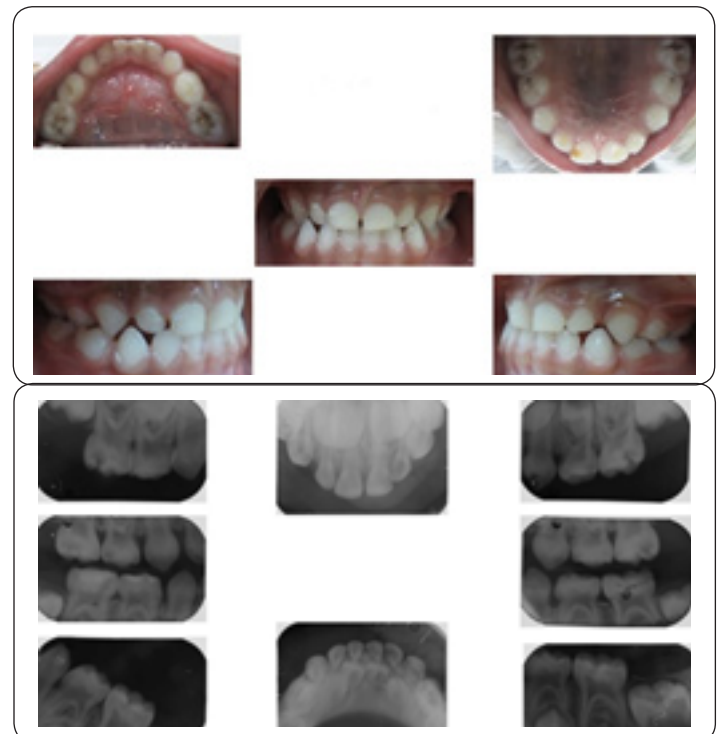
Intraoral and dental radiograph images before treatment
